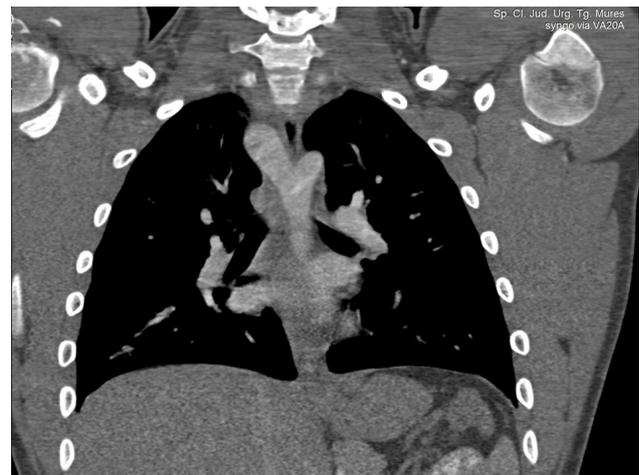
Thoracic CT angiography, coronal section . The the two AA are coming from the ascending aorta.
